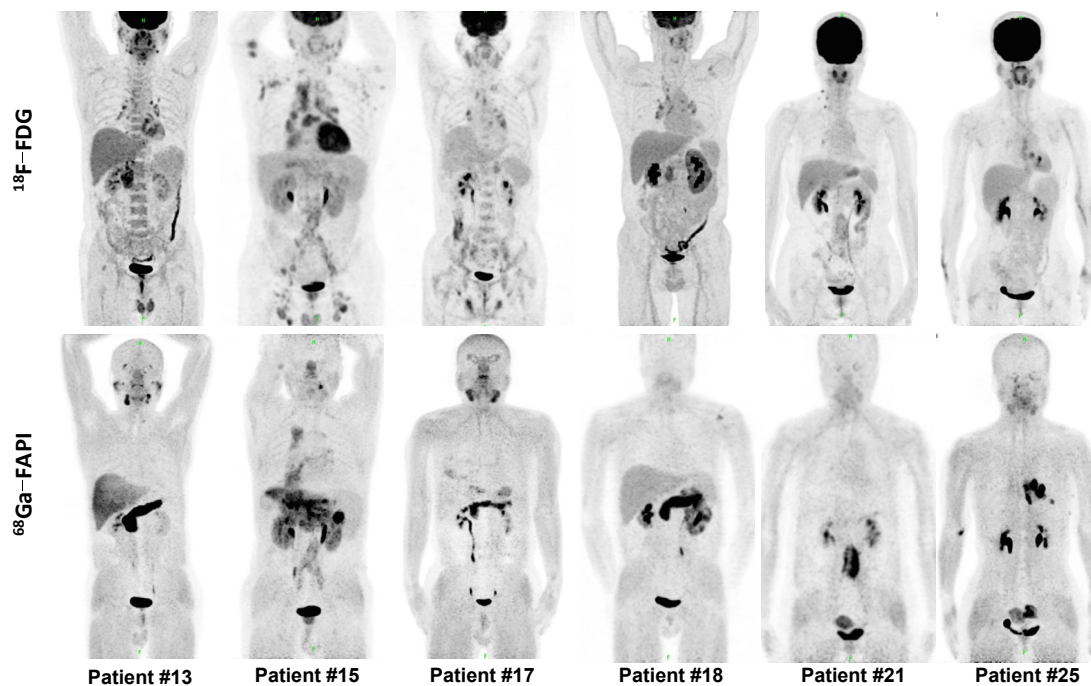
Intraindividual comparison of 6 patients with IgG4-RD undergoing ^{18}F -FDG and ^{68}Ga -FAPI PET/CT. Examples to show the superiority of ^{68}Ga -FAPI to ^{18}F -FDG in depicting involvements of IgG4-RD in the pancreas (patient #13, 15, 17, 18), bile duct/liver (patient #13, 15, 17), retroperitoneal fibrosis (patient #21), lung/pleura (patient #25), and salivary gland (patient #13, 17). Notice the hypermetabolic lymph nodes in ^{18}F -FDG PET/CT did not show uptake of ^{68}Ga -FAPI (patient #15, 17). Renal involvements (patient #15, 18) were both FDG- and FAPI-avid. There was also unspecific FAPI uptake in the uterus (patient #21, 25).
